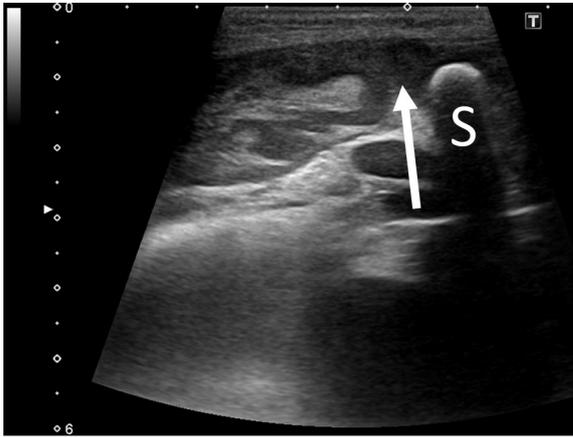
Midline transverse sonogram of the sternum showing disruption in the surface of the sternum, with purulent material (indicating by arrow) around the area of fracture of the sternum (S).
